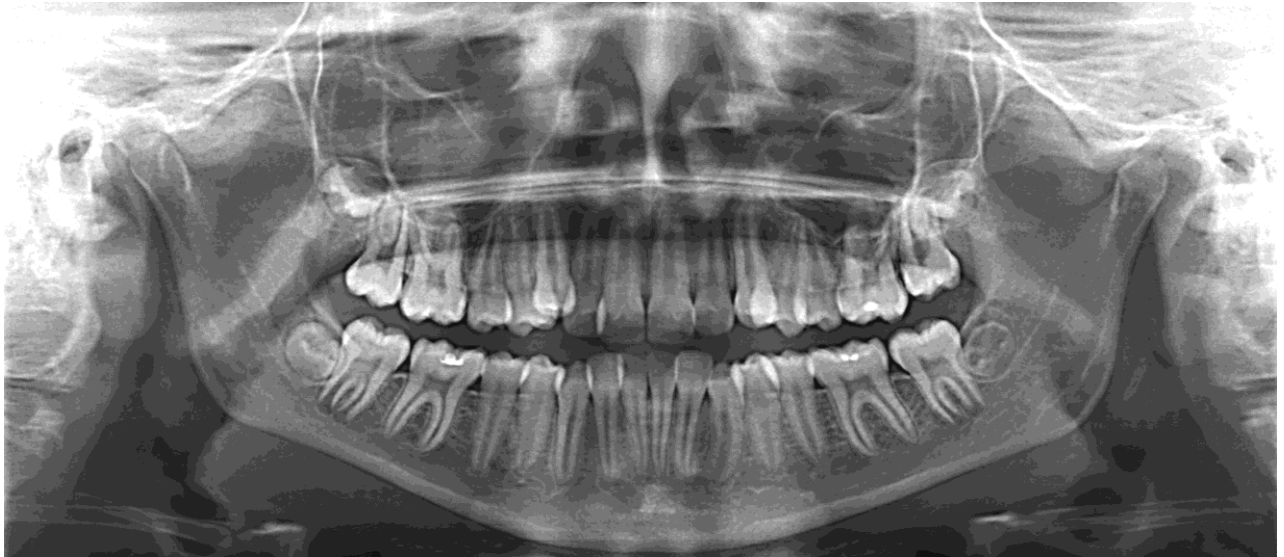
Panoramic X-ray picture at 13 years of age (permanent dentition)
